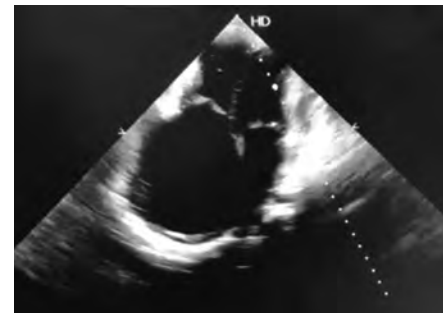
Apical four-chambered view showing grossly dilated Rt atrium
